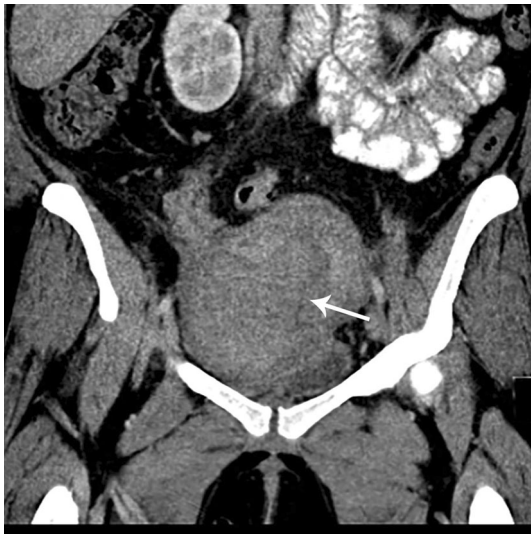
Uterine rupture on CT. Coronal CT shows a large area of complete myometrial disruption (*arrow*) with heterogeneous hypodense material extending from the endometrial cavity to the peritoneal space
